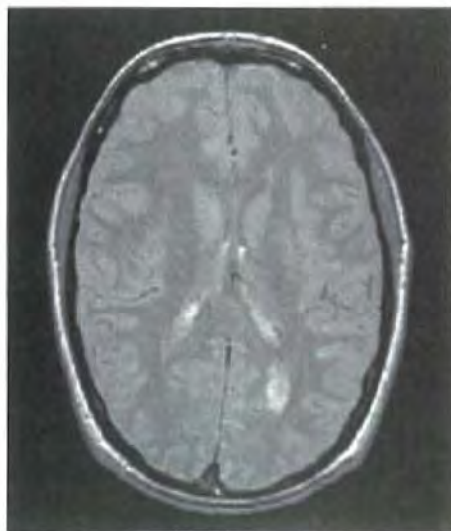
Multiple sclerosis. T₂-weighted MRI shows a lesion in the optic radiation.
